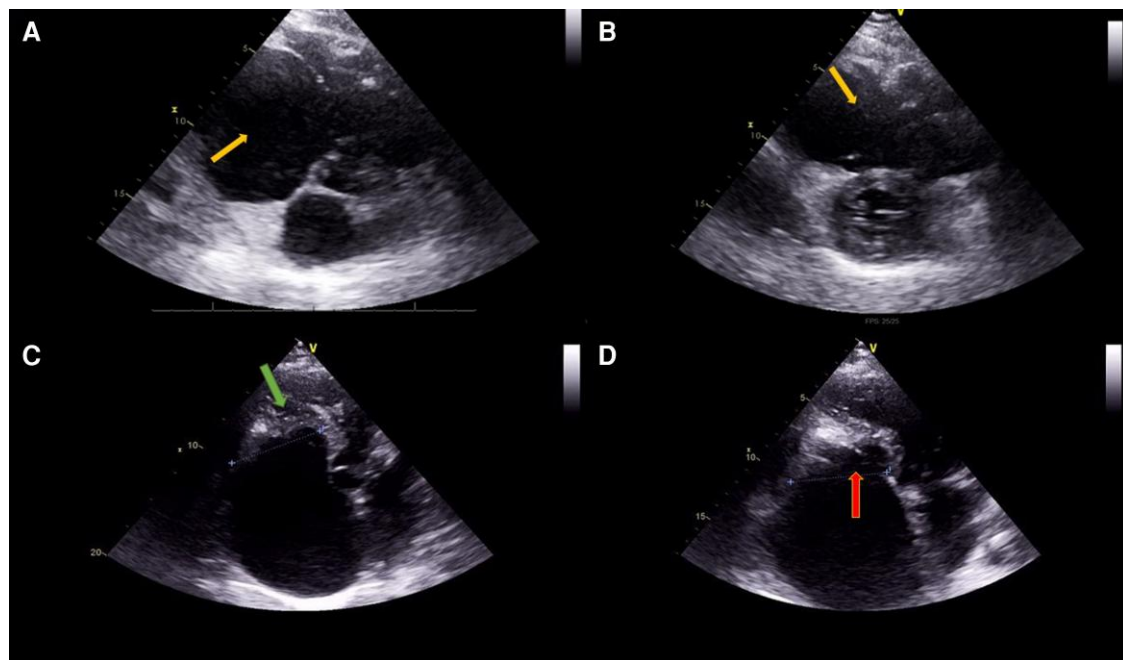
Transthoracic two-dimensional echocardiogram at short-axis view (A and B) showed severe dilatation of the right chambers (arrows). Apical four-chamber view (C) showed the right ventricle apical region with a homogeneous and hypoechoic image causing obliteration (arrow). Apical four-chamber view (D) showed dilatation of the tricuspid annulus, and severe tethering of the valve leaflets (arrow).
